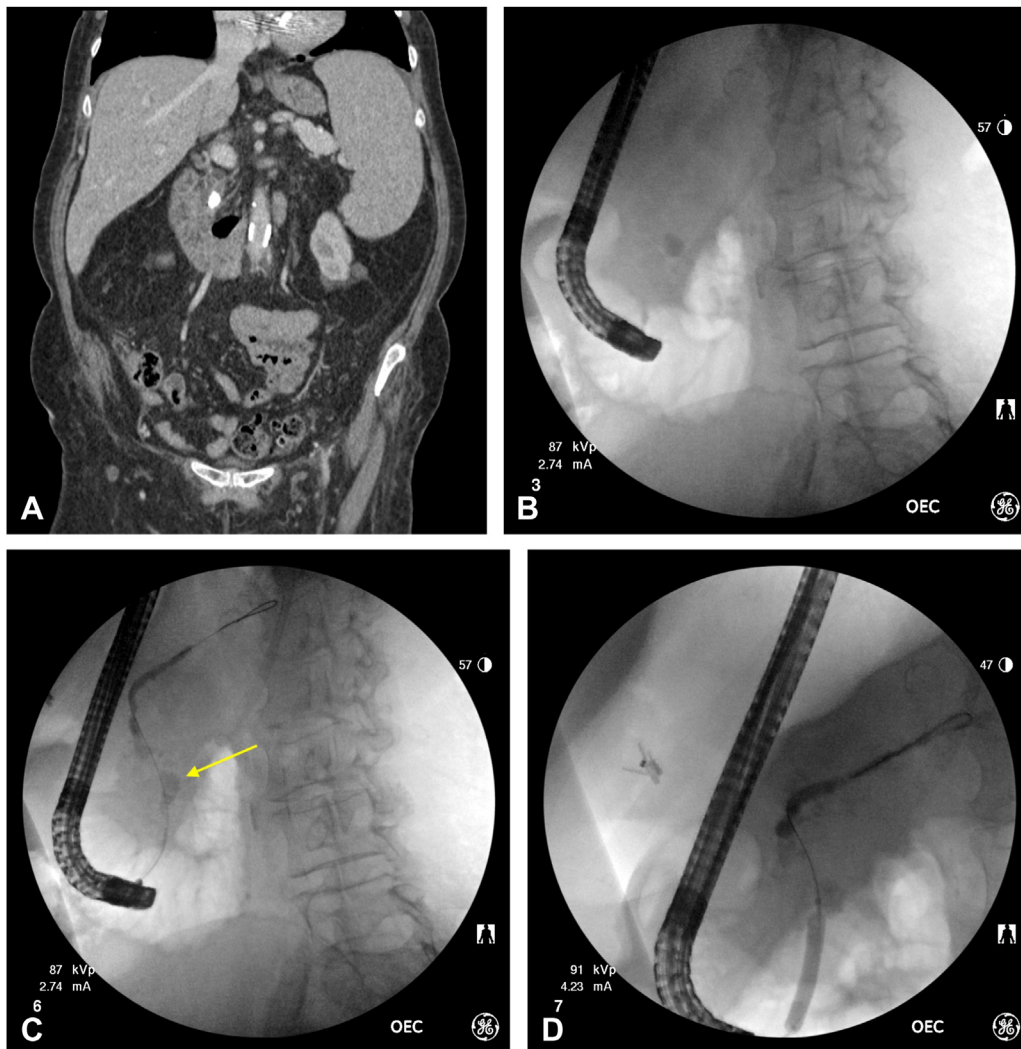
A, CT scan showing a large, obstructing, calcified stone in the head of the pancreas. B, Scout film demonstrating a radiopaque stone (*yellow arrow*) in the head of the pancreas. C, Wire advanced beyond stone (*yellow arrow*) and stricture with pancreatogram showing upstream ductal dilation. D, Balloon dilation of the duct in the head of the pancreas. This patient ultimately underwent extracorporeal shock wave lithotripsy and is stent free.
